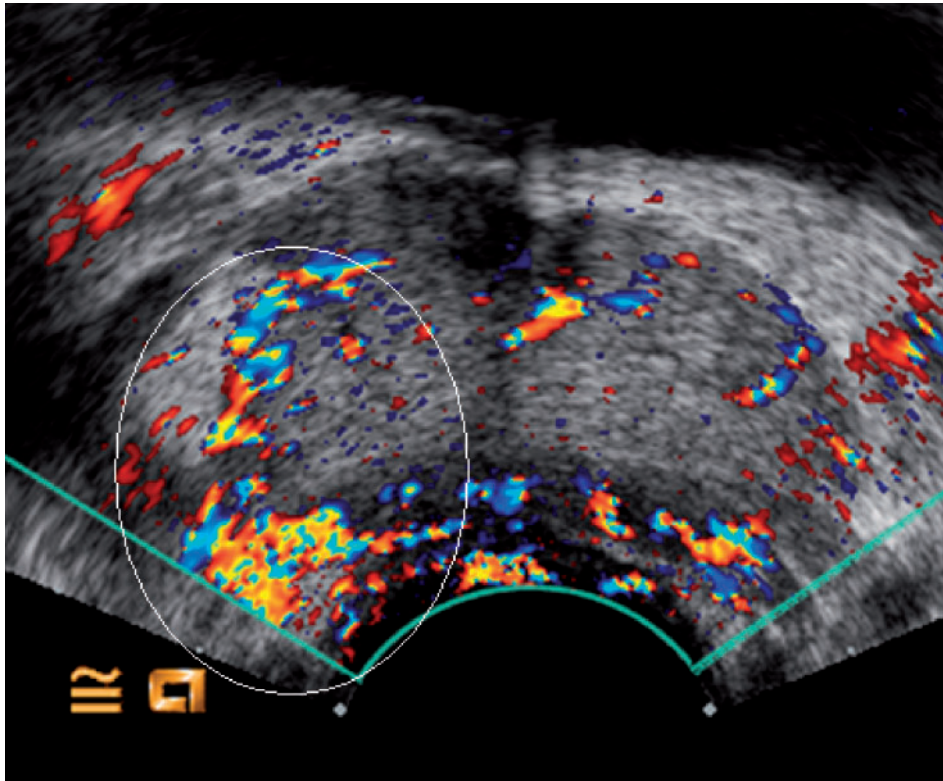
Corresponding contrast-enhanced colour Doppler US showing clearly more enhancement of the right side (white ellipsoid). Targeted biopsy revealed a cancer focus with Gleason score 3 + 4.
